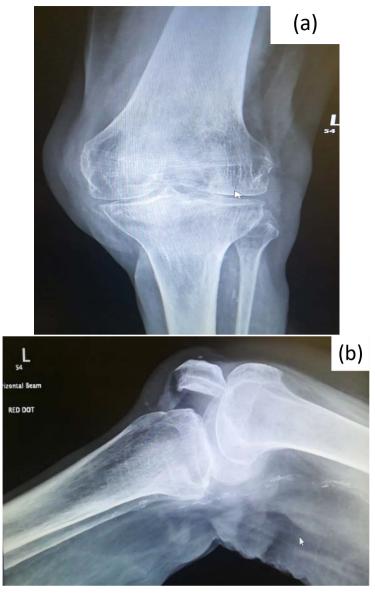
(a) Anteroposterior; (b) Lateral radiographs taken at the time of injury showing intra-articular patellar dislocation.
